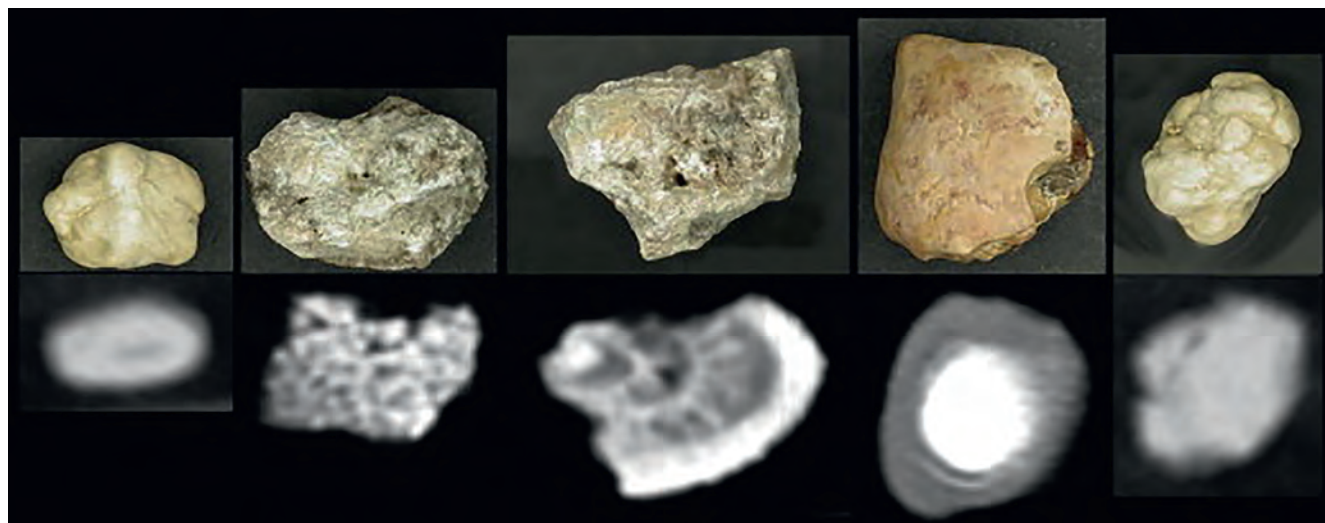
Photographic and helical computed tomography images show structural variability in stones of the same type. Note that although all stones depicted are calcium oxalate in type, some have a mottled structure and others have a lamellar structure.
